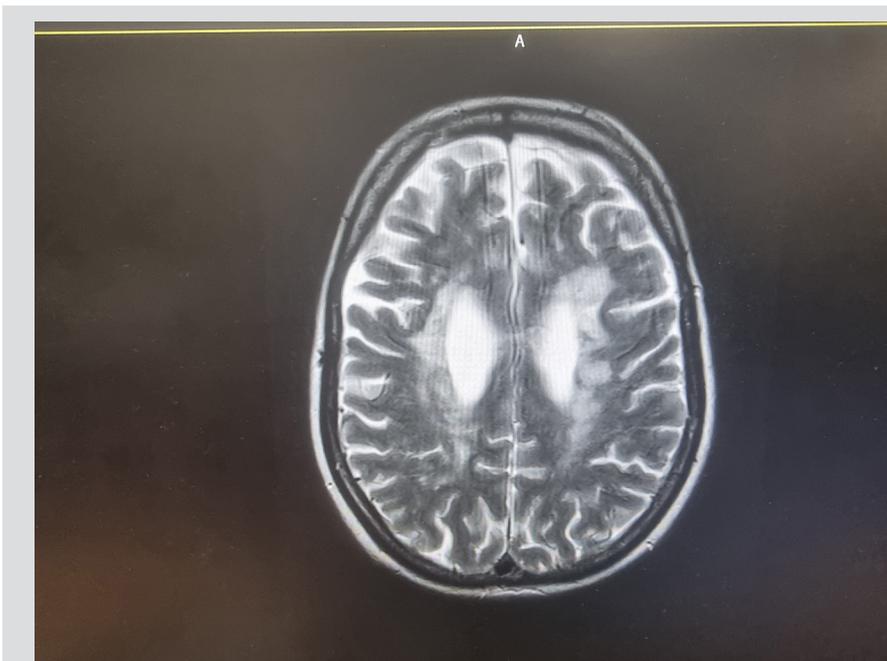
MRI of the head showing ischaemic damage of different ages in multiple vascular territories
